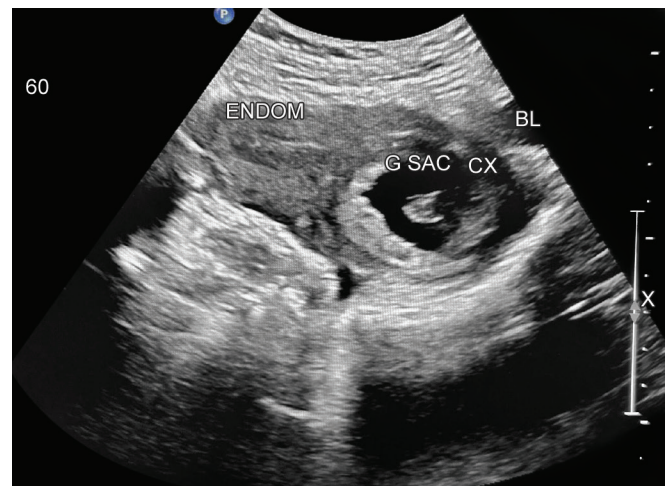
Ultrasound imaging
